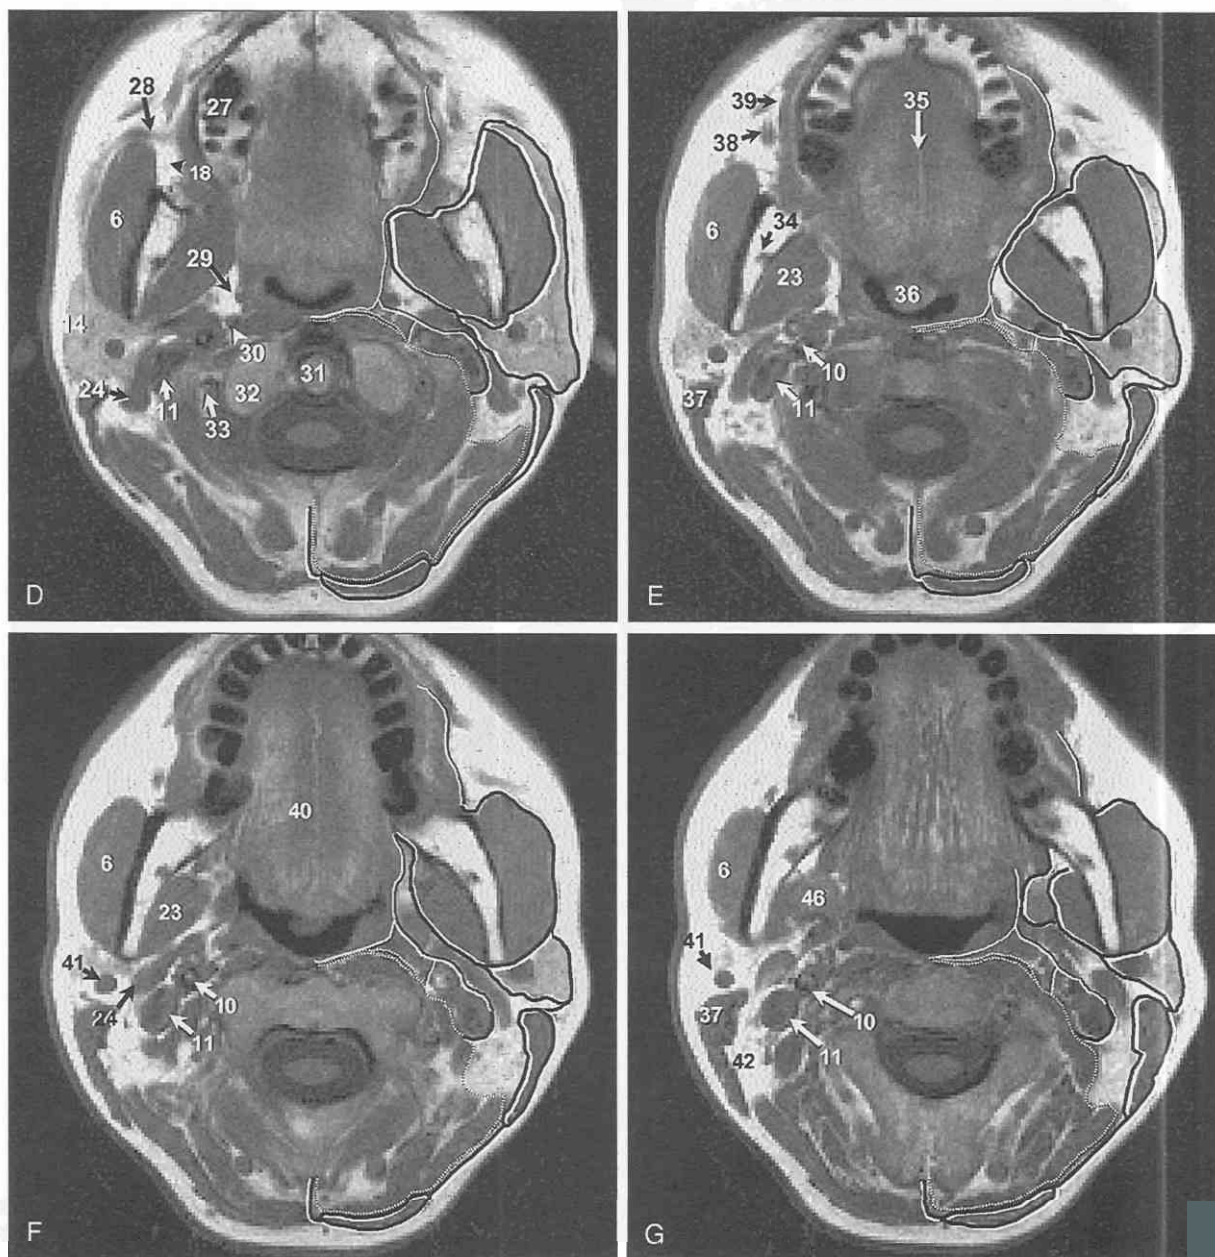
A–I, Normal imaging anatomy of the nasopharynx, oropharynx, and oral cavity on an axial nonenhanced, T1-weighted MR image. MS, masticator space; PMS, pharyngeal mucosal space; PPS, prestyloid parapharyngeal space; PS, perivertebral space; RPPS, retrostyloid parapharyngeal space (carotid space); RPS, retropharyngeal space. The central region of A is depicted (*inset*).
